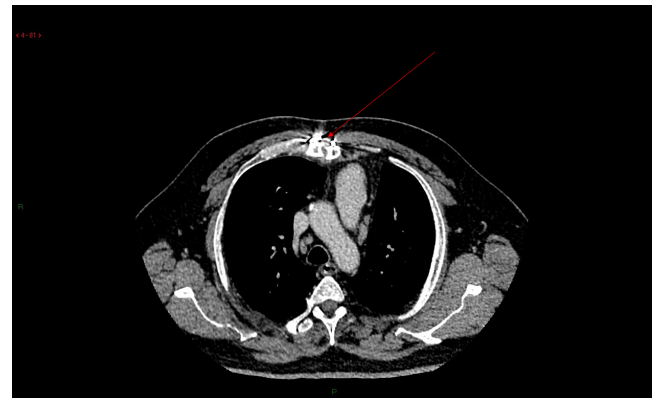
Computed tomography scan of thorax showing non-union of sternum (red arrow - sternal malunion)
